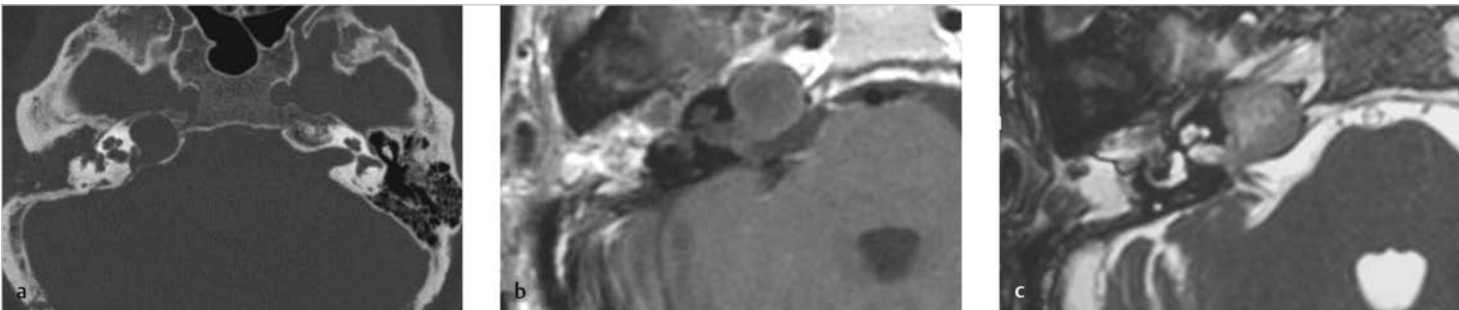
A case of right petrous apex cholesteatoma. (a) The CT shows expansive growth of a round-shaped lesion in the petrous apex of the temporal bone with a formerly operated open cavity. (b) The lesion shows slightly low signal in T1 image with gadolinium enhancement, (c) and slightly high signal in T2. Note faint enhancement in the margin of the lesion with no enhancement inside, and obvious enhancement in inflamed open cavity.
